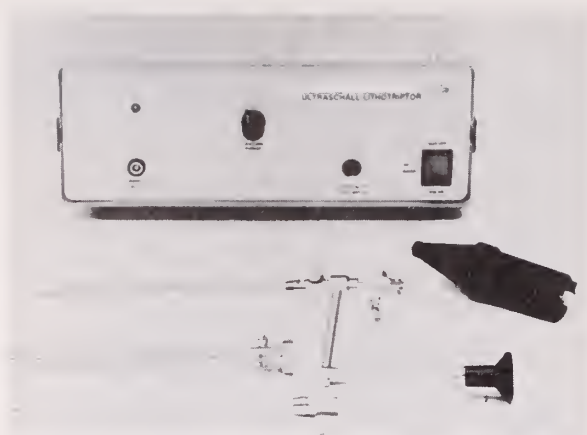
Nephroscope and ultrasound generator with transducer
